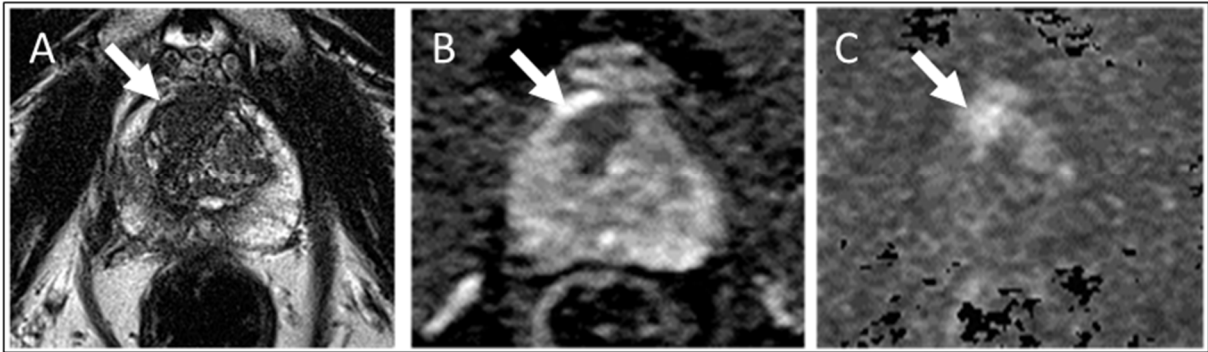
Example of a PI-RADS 5 lesion. The patient had received a negative systematic biopsy at PSA 11ng/ml. Six months later at PSA 17ng/ml a mpMRI is performed. (A) T2-weighted image shows an eroded charcoal sign of the anterior transitional zone of $>15\text{mm}$ diameter. (B) ADC-map showing a strong diffusion restriction (low signal intensity) in analogy to the T2-weighted image showing even clearer the suspicious lesion. (C) The corresponding high b-value image shows marked diffusion restriction (high signal intensity) in the anterior transitional zone.
